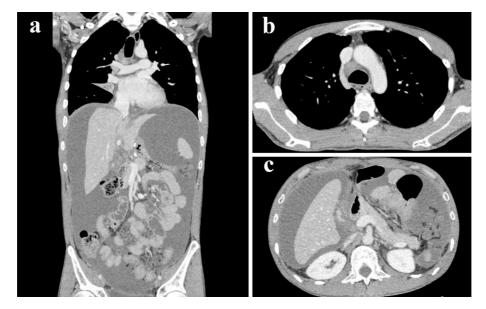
One year after postoperative adjuvant chemotherapy with S-1, the presence of ascites was evident on a follow-up CT scan. We switched the regimen to ramucirumab. After three cycles, a CT scan showed increased ascites (a), enlarged mediastinal lymph nodes (b), and peritoneal dissemination (c).
